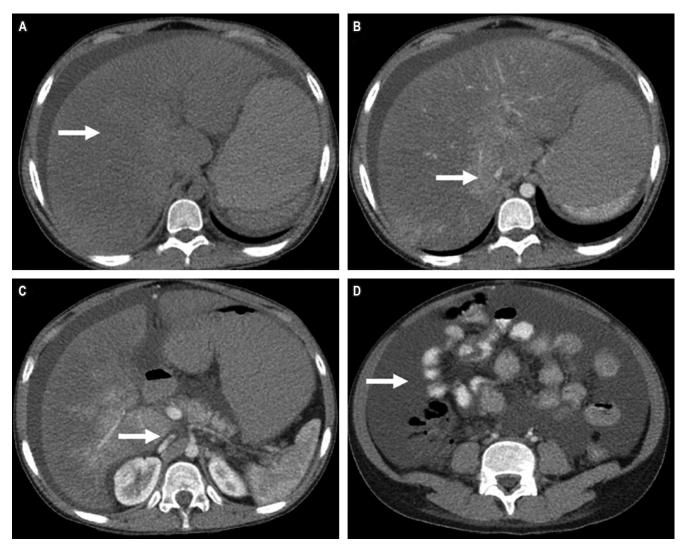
CT scan of the abdomen and pelvis. A. Phase without contrast shows hepatomegaly. B. Contrasted phase shows absence of suprahepatic vein flow. C. Contrasted phase shows compression of the inferior vena cava. D. Contrasted phase shows ascites.
